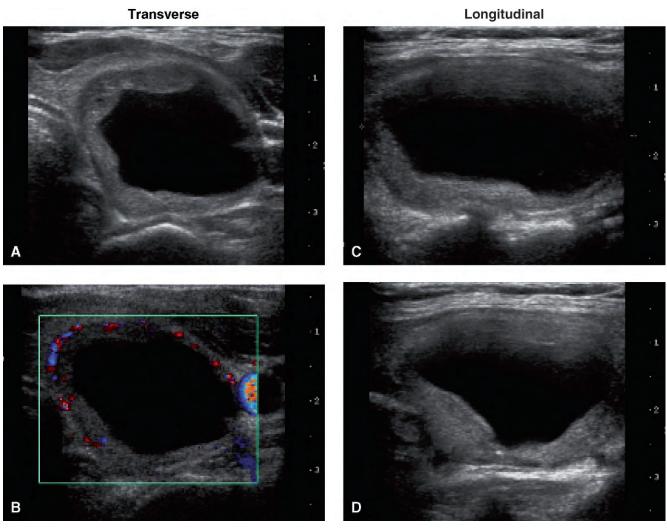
Ultrasound of follicular adenoma in the left lobe. A, Transverse. B, Color Doppler, transverse. C, Longitudinal, sagittal diameter: 40 mm. D, Longitudinal.
